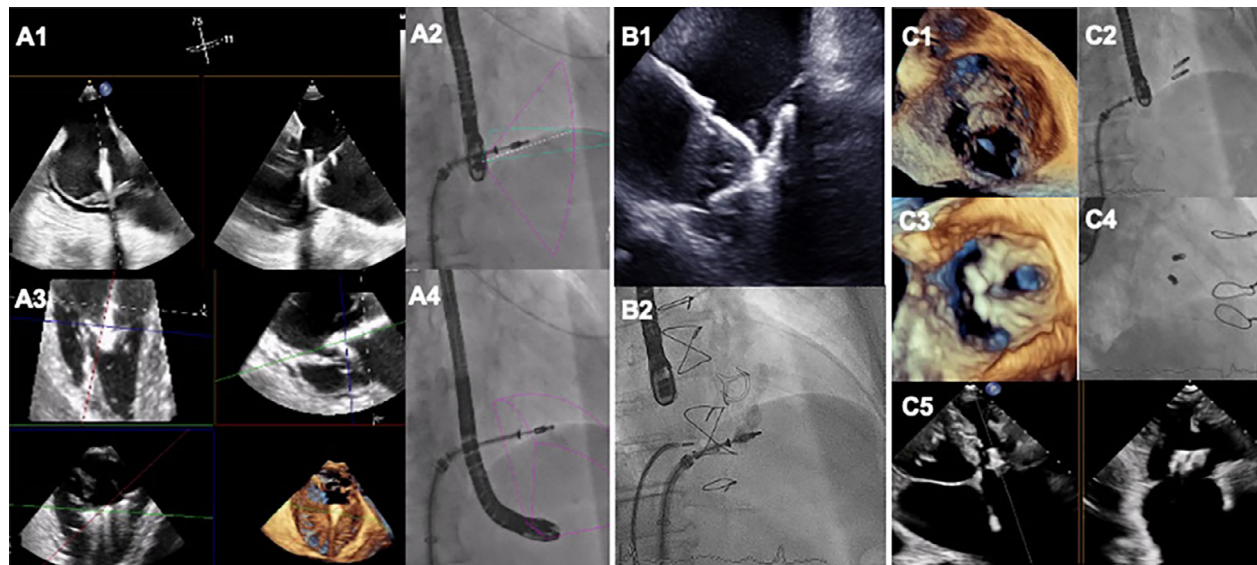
Contribution of imaging during transcatheter tricuspid valve edge-to-edge repair. Procedural guiding using live biplane transoesophageal views (A1) and transgastric views with multiplanar reconstructions (A3) in addition to fluoroscopy (A2, A4). Intracardiac echocardiography (B1) in addition to fluoroscopy (B2). Immediate post-procedural result using three-dimensional transoesophageal echocardiography (C1, C3), fluoroscopy (C2, C4) and biplane transthoracic echocardiography (C5).
